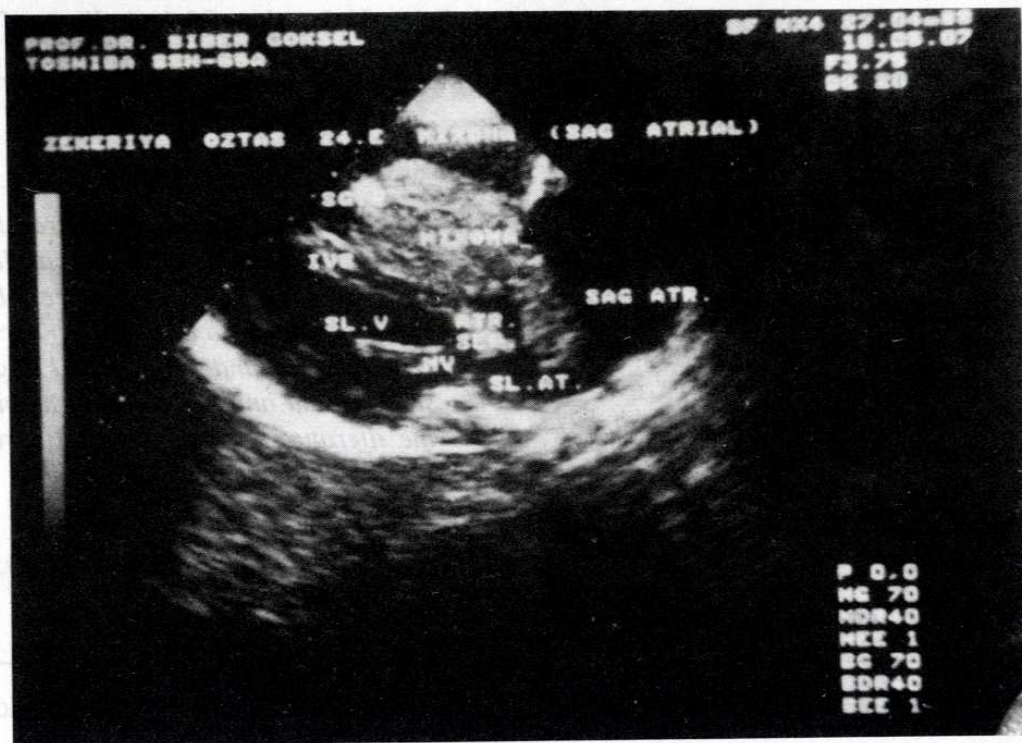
The preoperative doppler study of the patient
